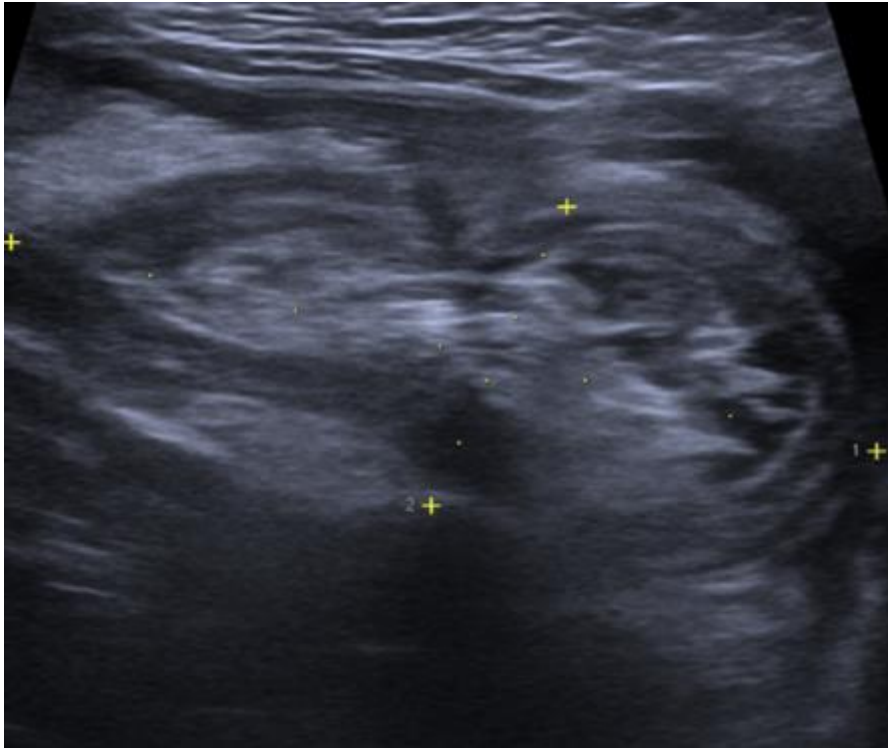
Ultrasound image of an ileoceco-colic intussusception, with D1 measuring 60mm and D2 measuring 23.8mm
